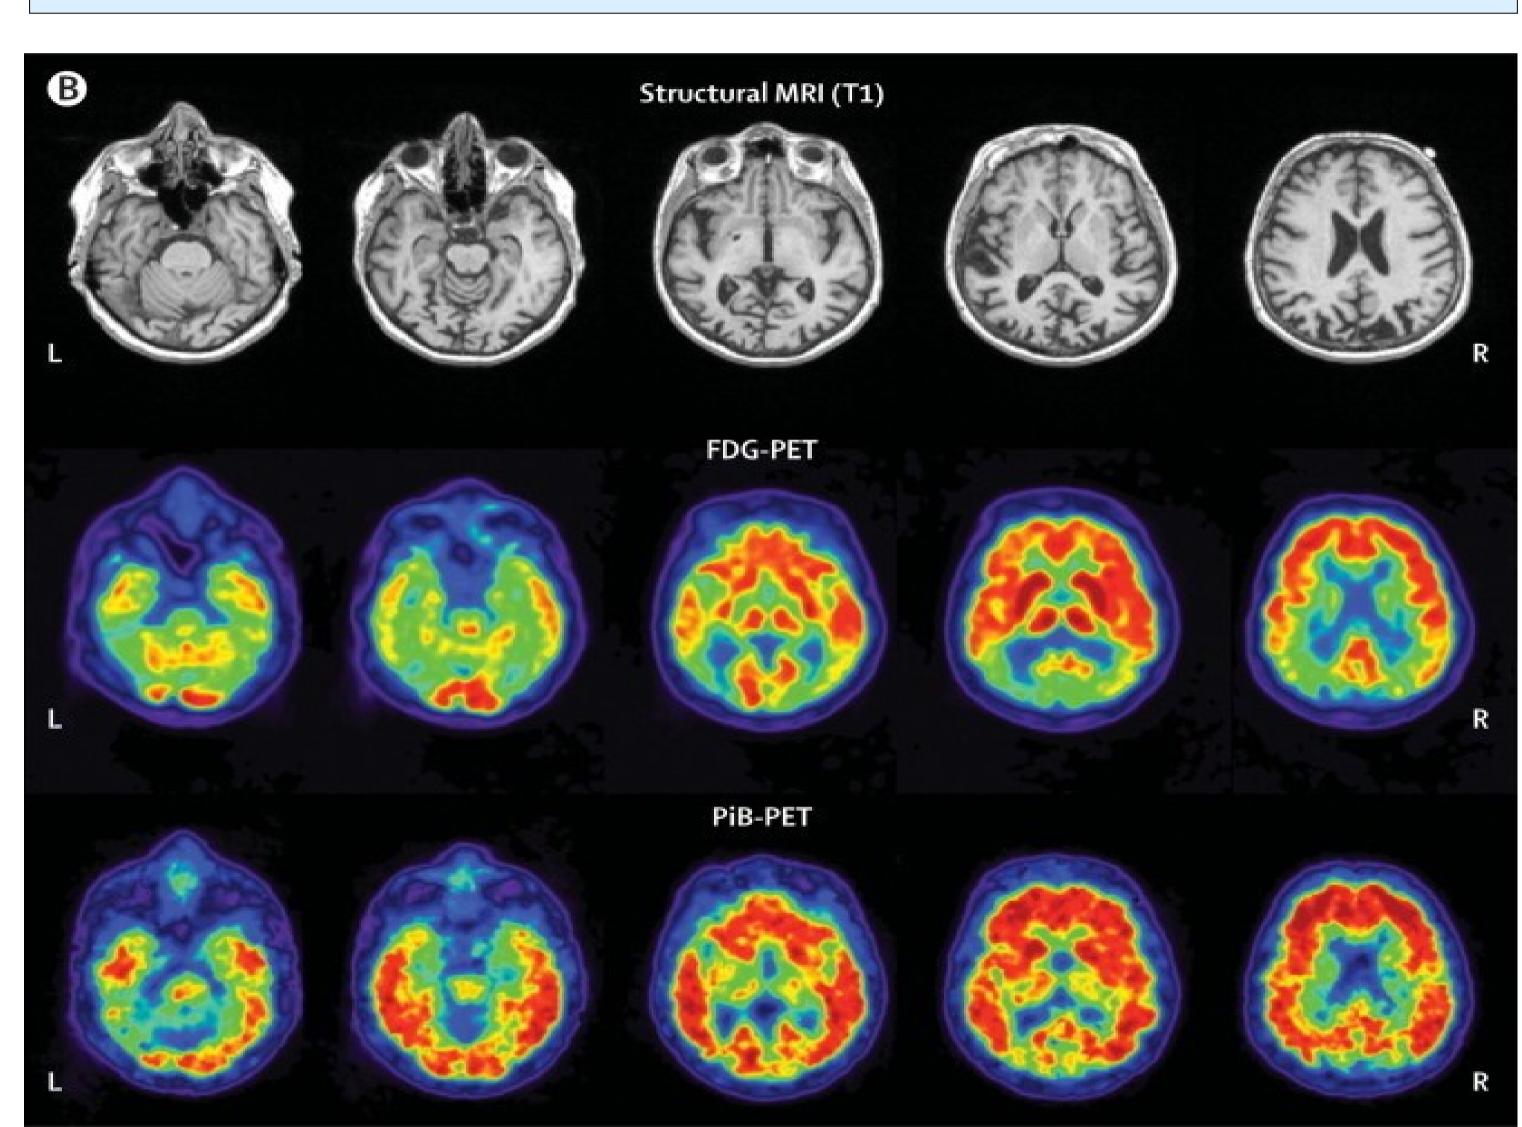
MRI and FDG-PET images of a 62-year old woman with visuospatial dysfunction due to PCA. There is atrophy in the bilateral parietal, posterior temporal and lateral occipital cortex (upper row). The FDG-PET data (middle row) showed hypometabolism in the same regions. PiB-PET data (lower row) showed diffuse cortical uptake throughout both posterior and anterior regions, suggesting the presence of amyloid-beta plaques. [1]
